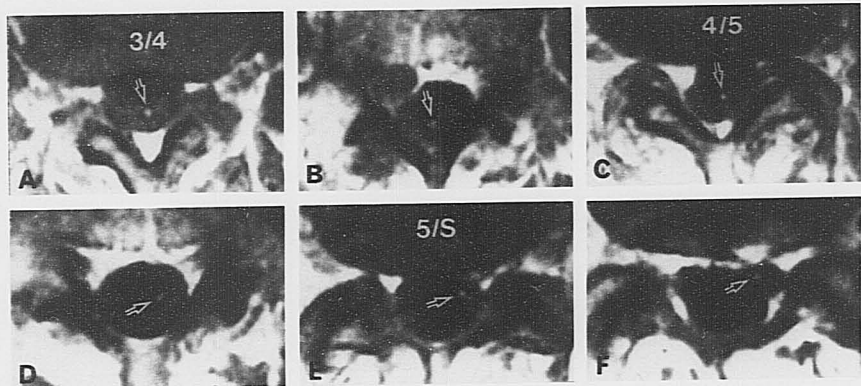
A 58-year-old man with herniation of L4/5 intervertebral disc. He suffered from anterior leg pain in the right side due to L4 and L5 radiculopathy. A-F: Consecutive enhanced MR images from L3/4 to L5/S1 level do not demonstrate the enhancement of the affected nerve roots but show small enhanced signals along a nonaffected S1 nerve root on the opposite side (arrow). This small image is thought to be a radicular vein. B: The herniated disc in L4 pedicle level.
